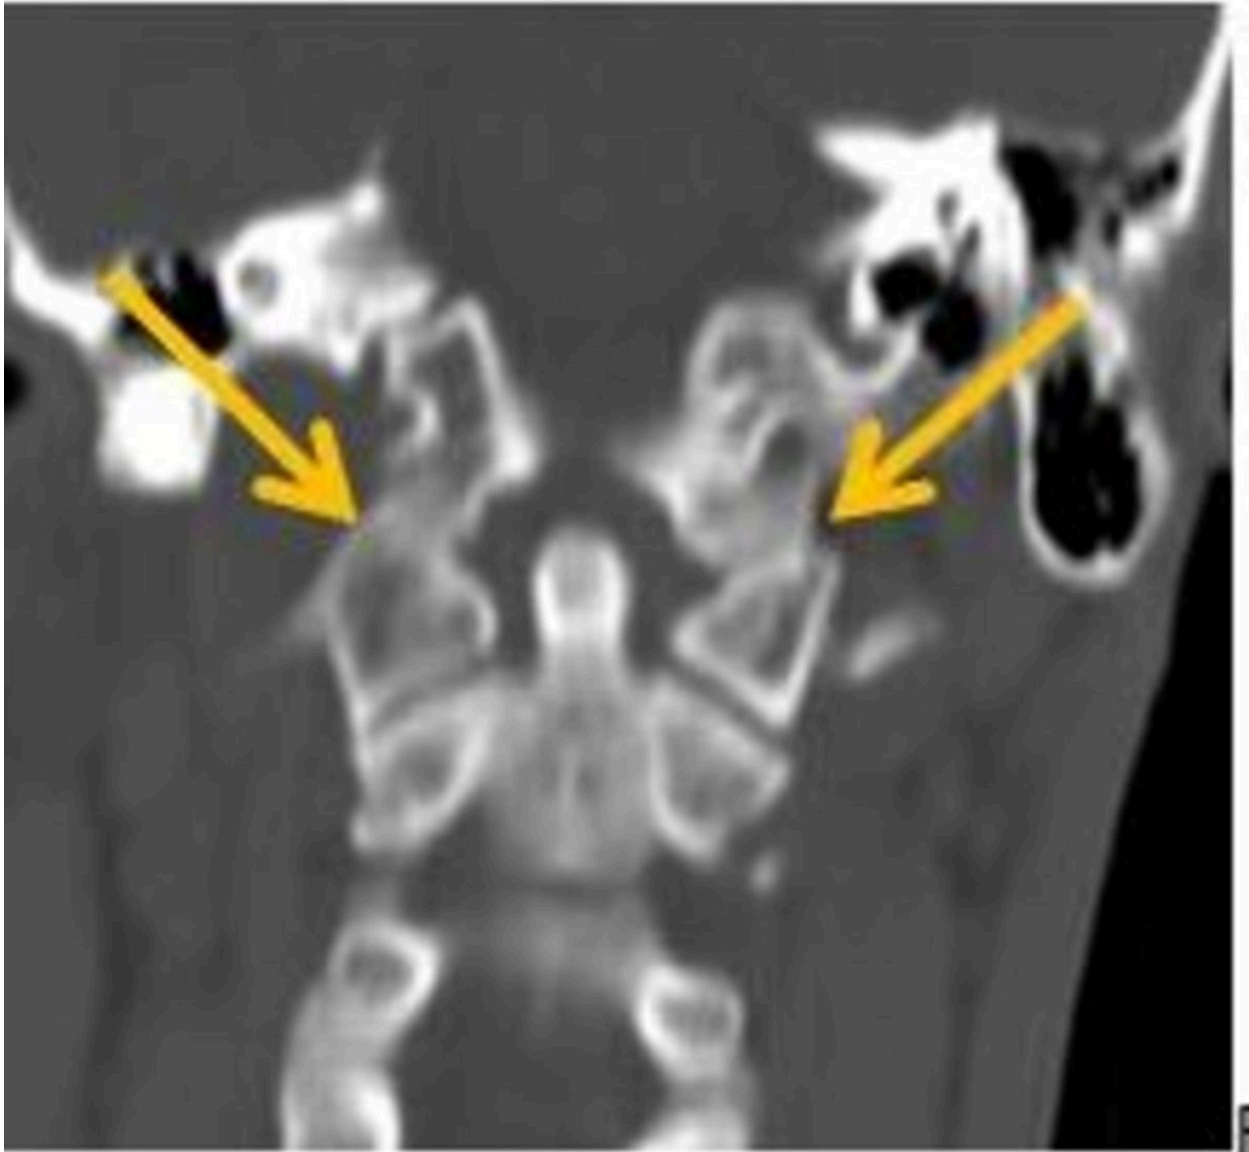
CT coronal section showing complete atalantooccipital assimilation on right side and incomplete atlanto-occipital assimilation on left side
